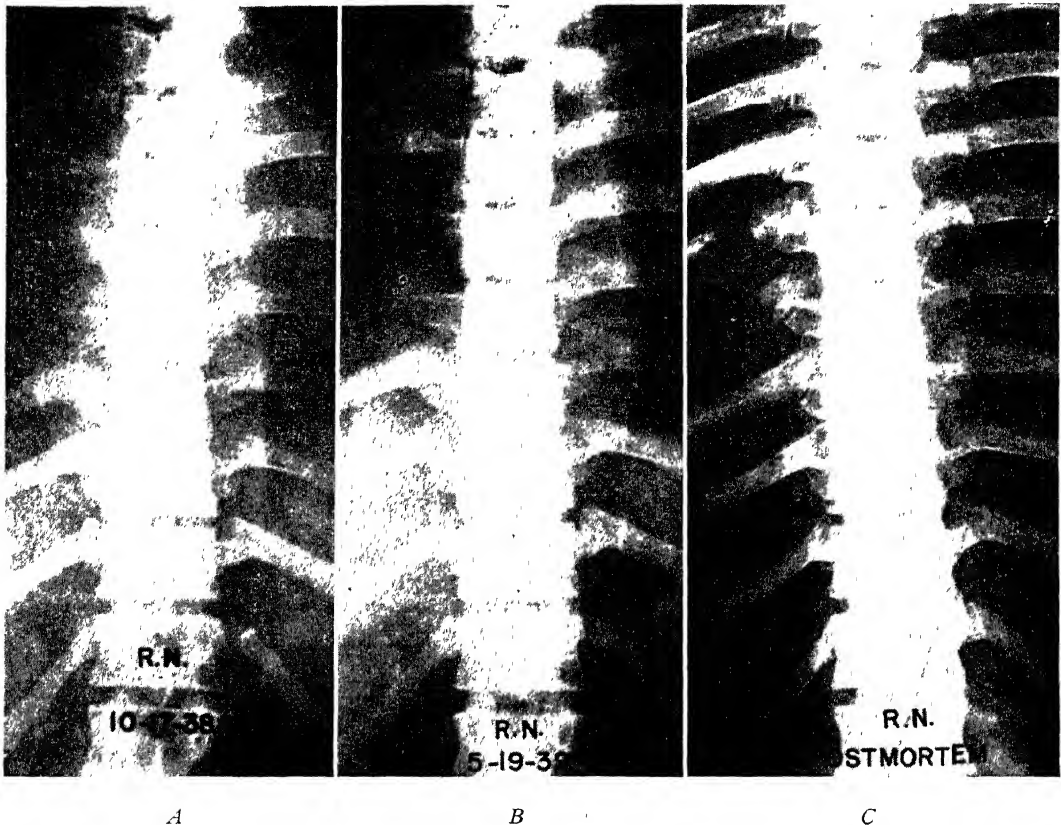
A*, R.N. Paravertebral shadow of third to twelfth thoracic vertebrae with slight narrowing of the disk of the seventh thoracic vertebra. *B*, Shadow of the paravertebral abscess has decreased in the seven months following spine fusion. *C*, X-ray just before autopsy. Five years since *A* (Bosworth, D. M. J Bone & Joint Surg 27: 491 (July) 1945)
